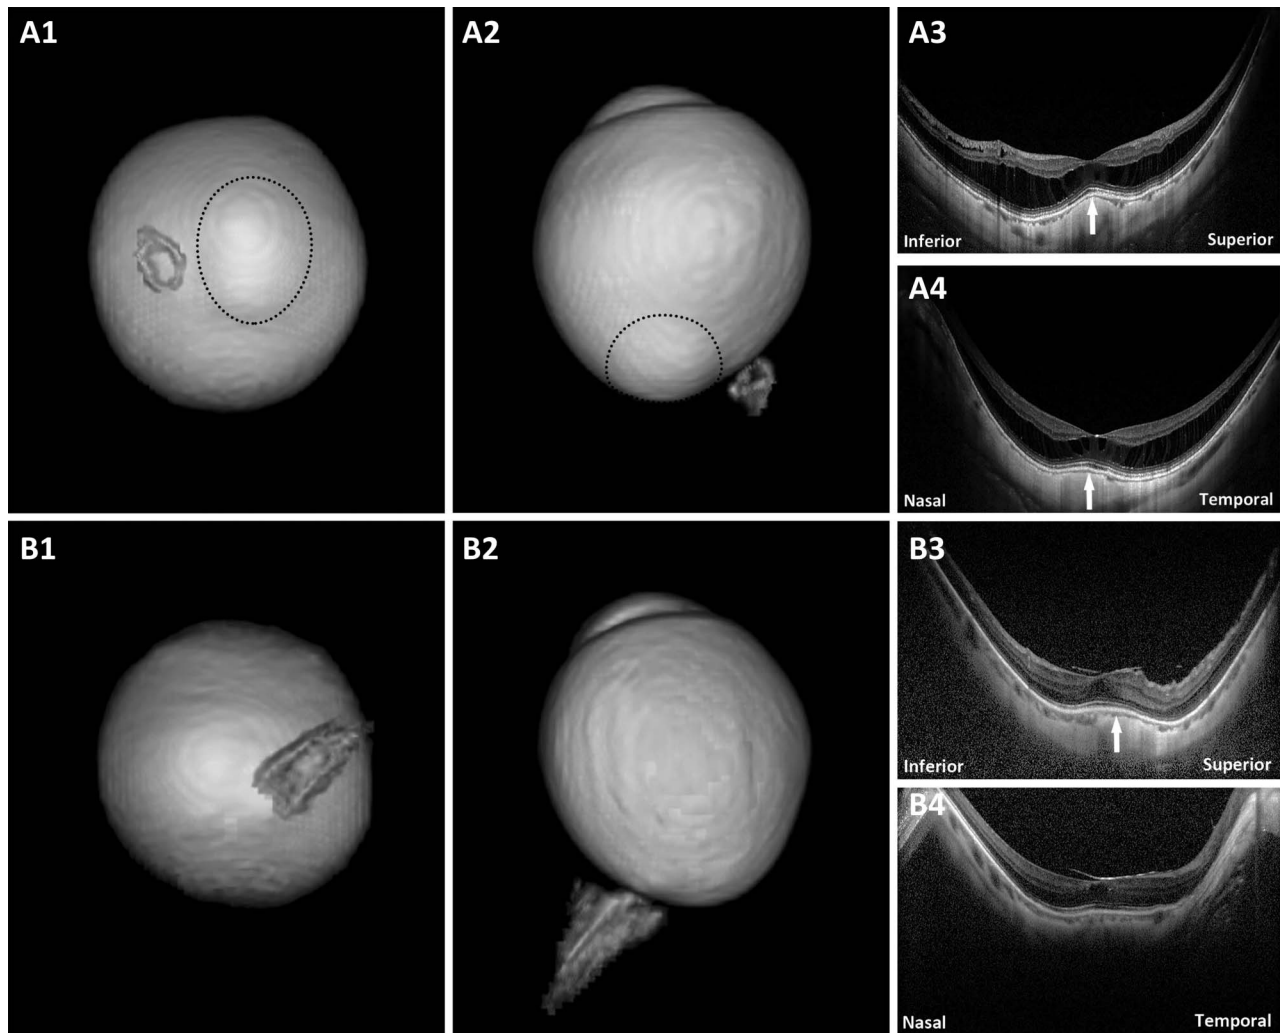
Eyes with a DSM on OCT but with no macular inward convexity on 3D MRI. A1 and A2. Posterior view and side view of 3D MRI of the eye. A staphyloma (circle) is observed; (A3 and A4) both vertical and horizontal scans show a convex macula (arrows) and obvious macular retinoschisis. No obvious dome-shaped convexity of the vitreoretinal interface is observed. B1 and B2. Posterior view and side view of 3D MRI of the eye. No protrusion or inward convexity is observed; (B3) vertical scan shows a clearly convex macula (arrow) and obvious macular pucker and a small foveal cystoid space. No obvious dome-shaped convexity of the vitreoretinal interface is observed; (B4) horizontal scan shows a flat macula and obvious macular pucker and a small foveal cystoid space.
